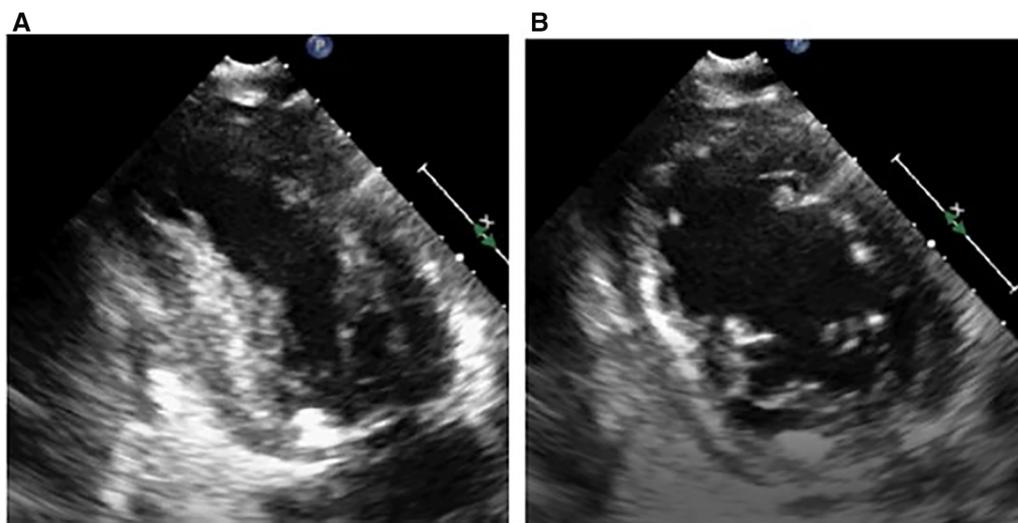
Transthoracic echocardiography images (A) Systole and (B) Diastole, showed hypokinesia of the apex.
